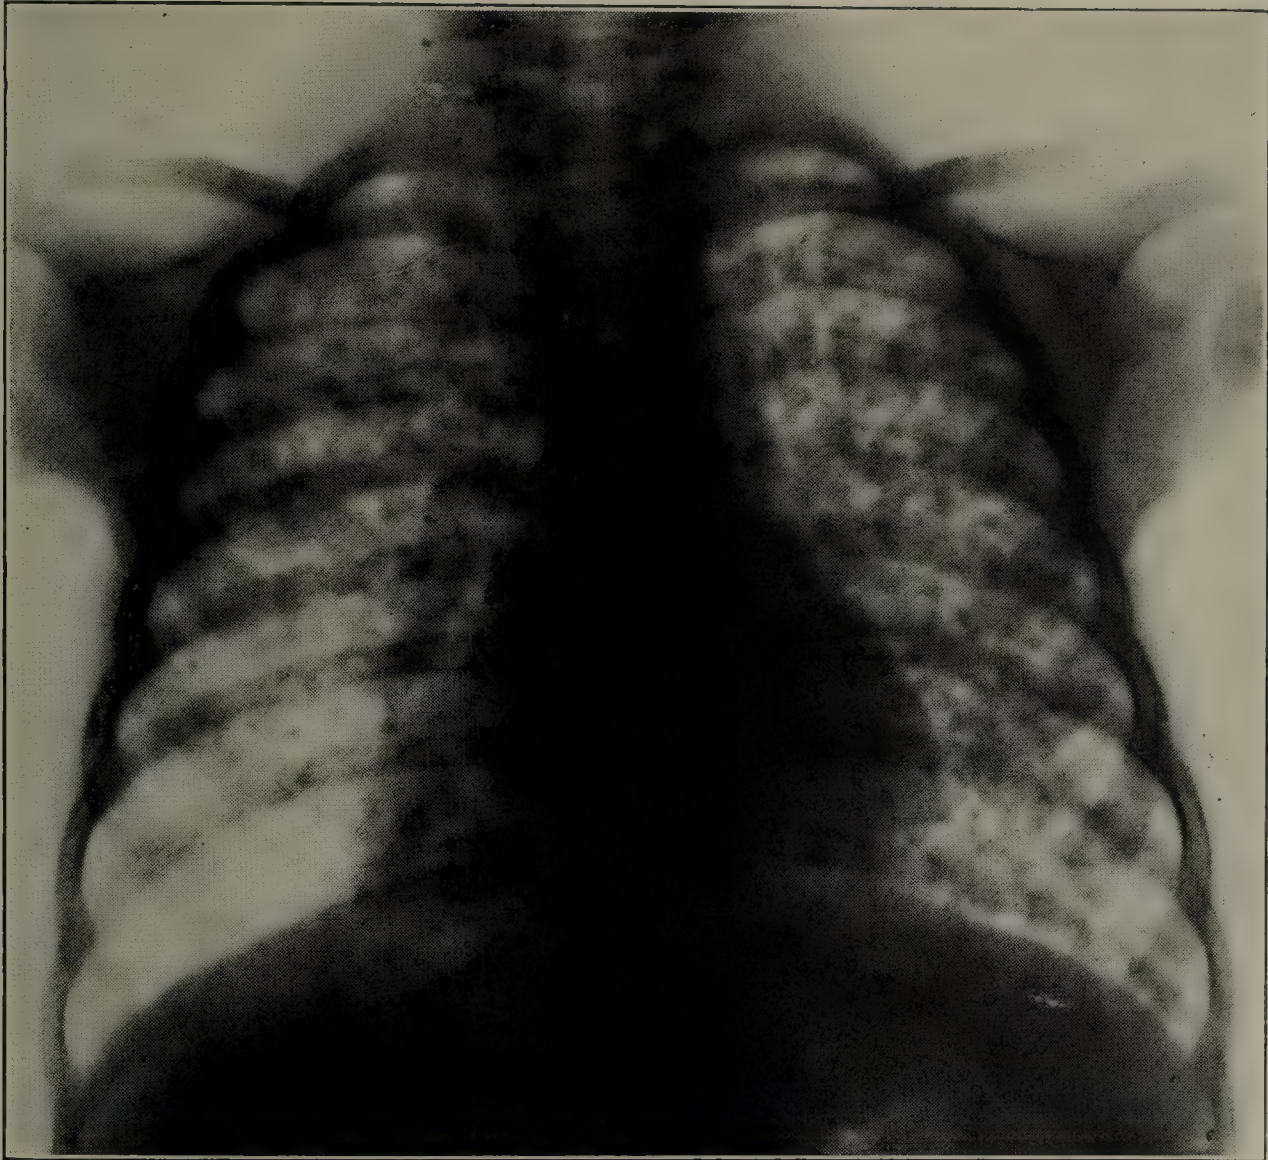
ROENTGENOGRAM IN ACUTE MILIARY TUBERCULOSIS.
